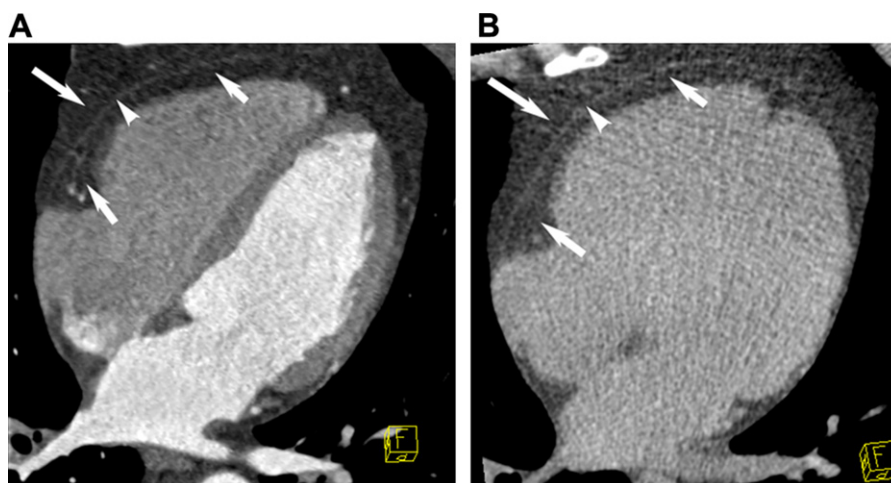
Multiplanar reconstruction resembling echocardiographic 4-chamber view in contrast enhanced (A) and nonenhanced (B) CT data sets show pericardial fat (short arrows), paracardiac fat (long arrow), and the pericardium (arrowhead).
